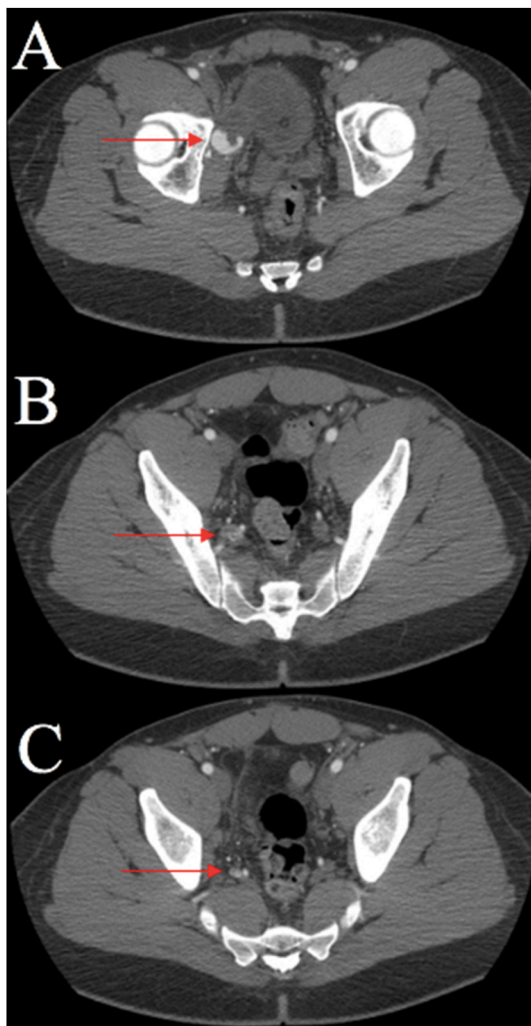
CT angiography. A) Blush in AVF. B) Active extravasation within AVF. C) Early draining vein consistent with AVF.
